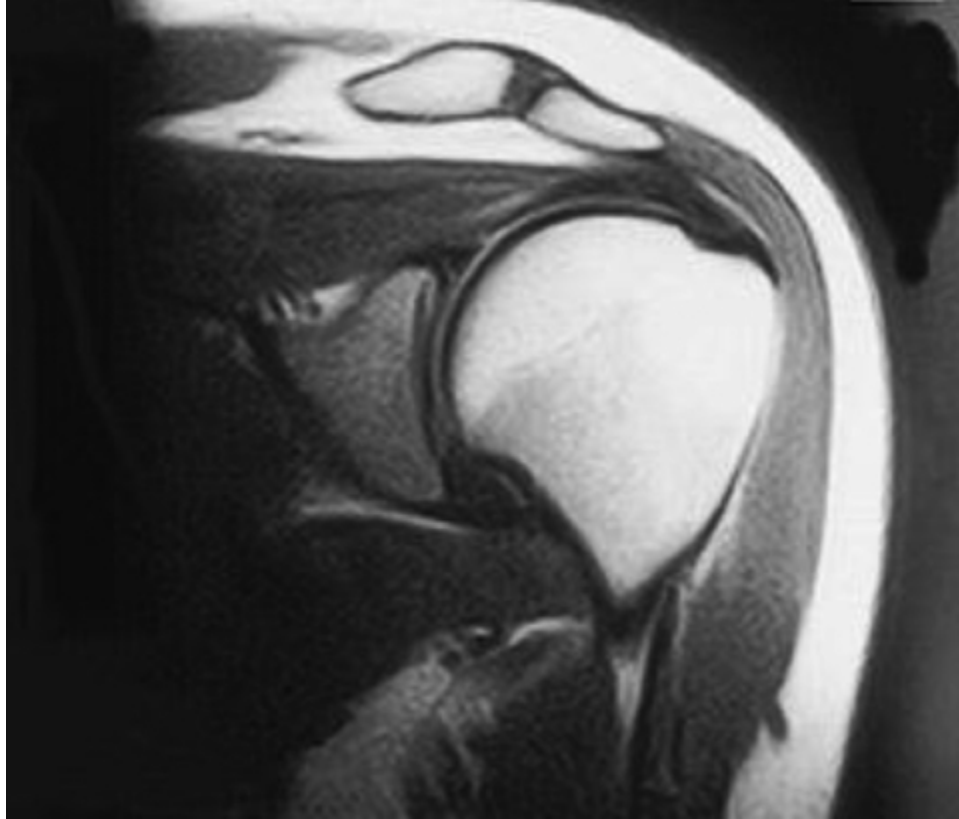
MRI of the shoulder shows the relevant soft tissue anatomy. Note how the supraspinatus tendon inserts in the sulcus at edge of articular surface.
